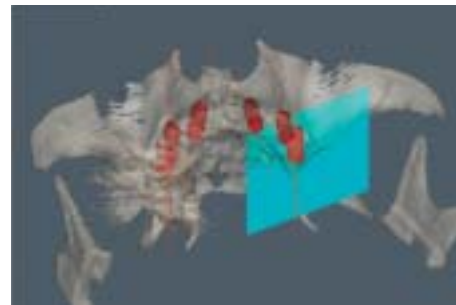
CT showing 3-D image of implant position relative to each other
